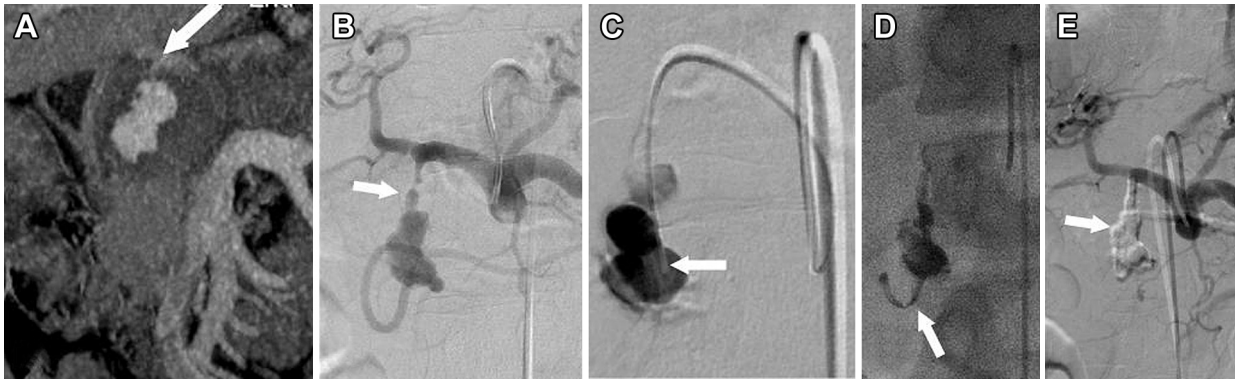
A 35-year-old male with chronic pancreatitis presented with recurrent abdominal pain. Contrast-enhanced computed tomography and digital subtraction angiography shows the pseudoaneurysm (A, arrow) arising from GDA origin (B, arrow). (C) As distal access was not achieved and there was only a short stump, direct injection of *N*-butyl cyanoacrylate into pseudoaneurysm done with the microcatheter tip positioned within the pseudoaneurysm (arrow). (D) Note the reflux of glue into the distal feeders (arrow). (E) Complete isolation of pseudoaneurysm achieved (arrow).
